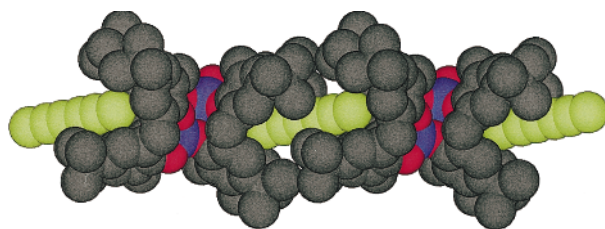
A portion of the X-ray structure of the koilate formed between the koiland 12 and hexadiyne as the connector. The one-dimensional network is obtained by a single translation of the assembling core defined by the inclusion of the connector into the cavity of the receptor. For the sake of clarity, the carbon atoms of the connector are coloured in green and the hydrogen atoms are not presented.
